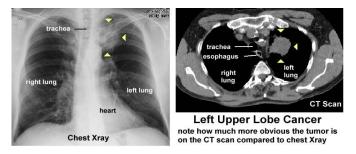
show role of CT scan to diagnose cancer
